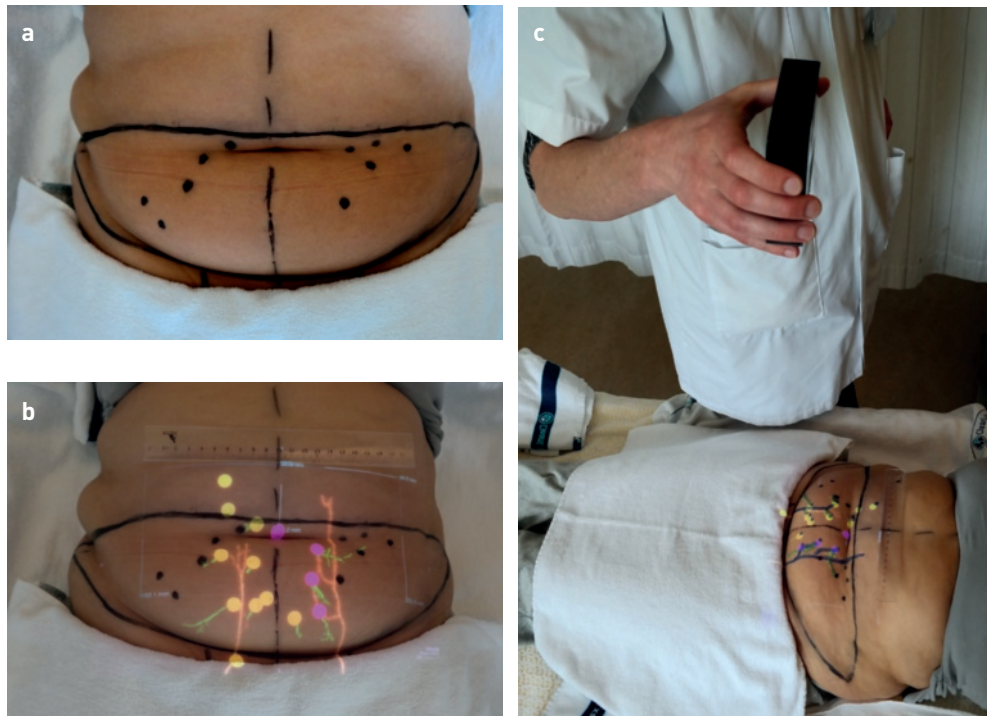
Handheld projection method. a) Black dots are determined following the standard Doppler protocol. b and c) The colored image is subsequently projected, showing the intramuscular (orange) and subcutaneous (green) branching pattern of the DIEA with its perforators (yellow and purple). A ruler is used to ensure an accurate scaling of the projected image.
